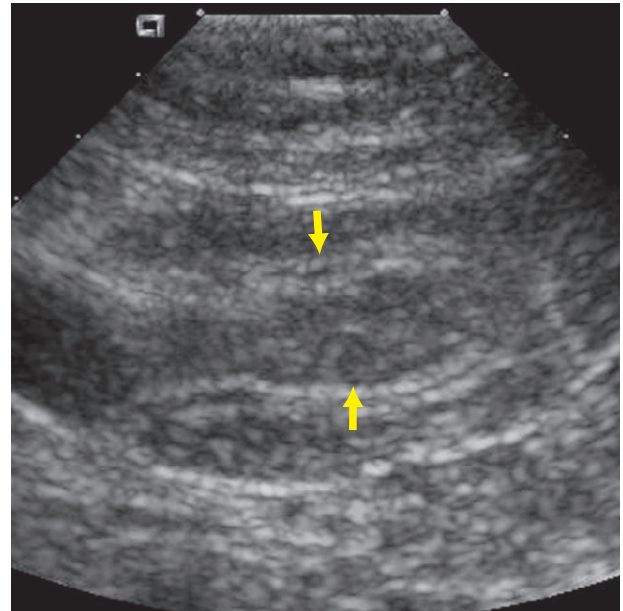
Longitudinal ultrasound of structure in RLQ of the abdomen in area of pain show the intussusceptum (arrow) inside the intussuscipiens.
